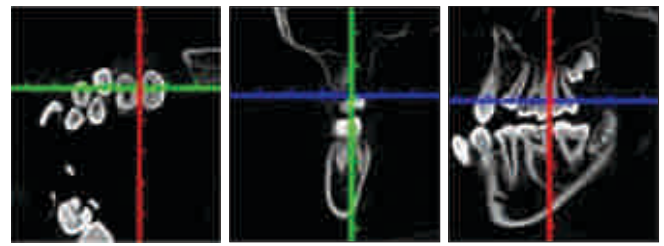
Orientation of CBCT
